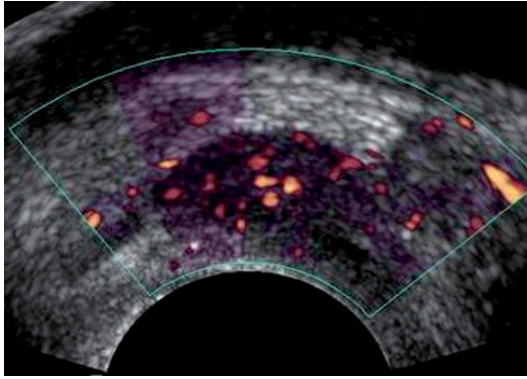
Ultrasonography with contrast medium and color Doppler. Transrectal approach, axial scan. The color effect has been strengthened in the central part of the gland
